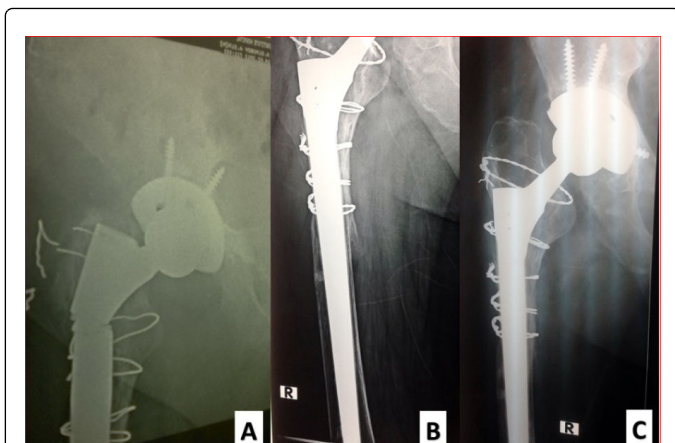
Follow up X-ray with bone osteointegration A) 6 weeks postoperative; B) X-ray three years postoperative.
